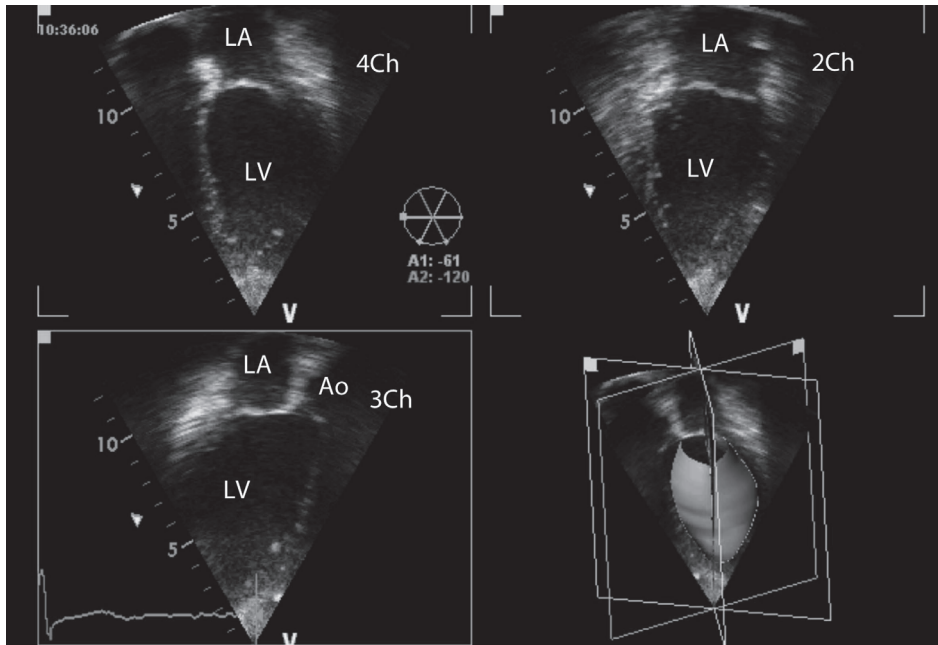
‘Triplane’ view of the left ventricle. This view permits visualisation of the apical four-chamber, two-chamber and three-chamber views as well as the volume defined by the endocardial border of the three reference planes.
